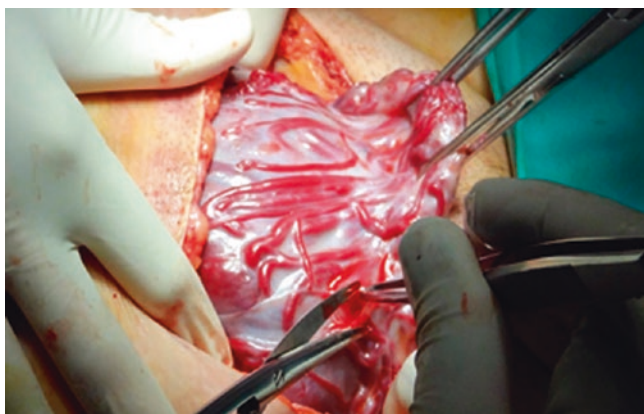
Laparotomy aspect after cesarean. Patient with one cesarean and one cesarean scar pregnancy treated with methotrexate, embolization, and curettage. Spontaneous pregnancy 5 months after second pregnancy. Although clinical aspect is evident, two previous ultrasounds showed neither AIP nor doubt either
